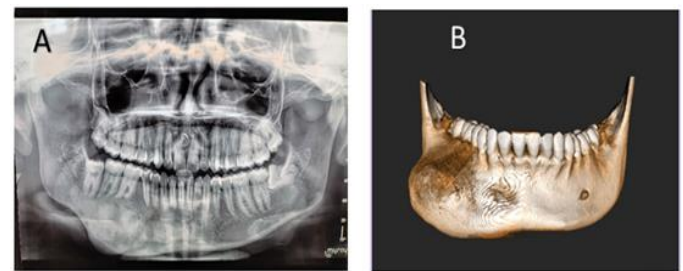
Pre- operative : Orthopantomogram (A) and Cone beam computed tomography (CBCT) (B)
